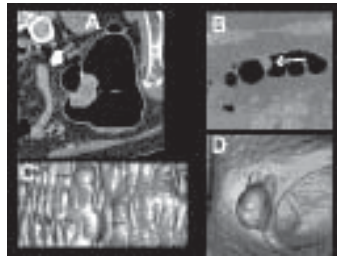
A-D, CT delineation of polyps. Transaxial NECT image in soft tissue window settings (A) shows a sessile polyp in the left colon (arrow) ; Image in lung window settings (B) shows a small sessile polyp; Panoramic display image (C) showing two sessile polyps; Perspective image (D) showing a large polyp on the endoluminal image
